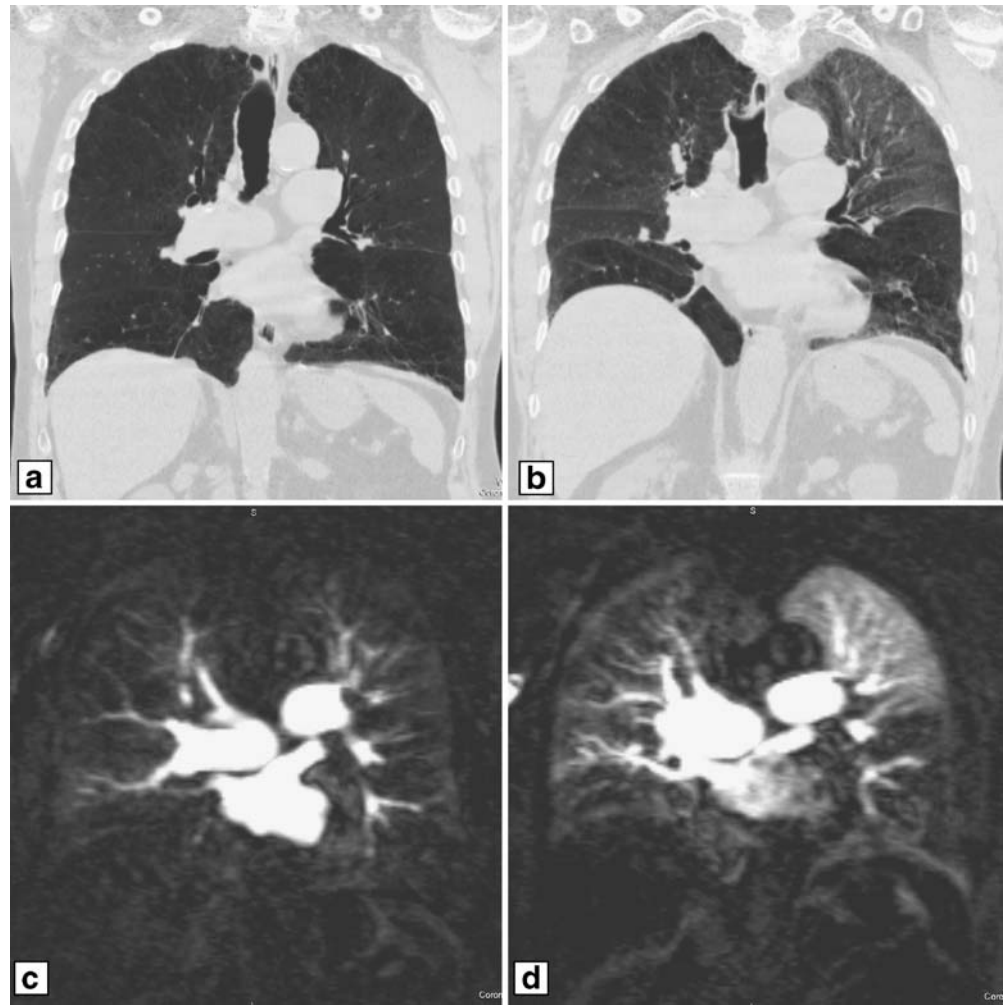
Coronal CT reformat at maximum inspiration (a) and maximum expiration (b) presented as 5-mm minimum intensity projection (MinIP): air-trapping in the right and left lower lung, physiological increase in density in the left upper lung in expiration. Corresponding subtracted coronal contrast-enhanced MR perfusion (10-mm MIP): low perfusion at inspiration (c) with a distinct increase in particularly in the left upper lung at expiration (d)
